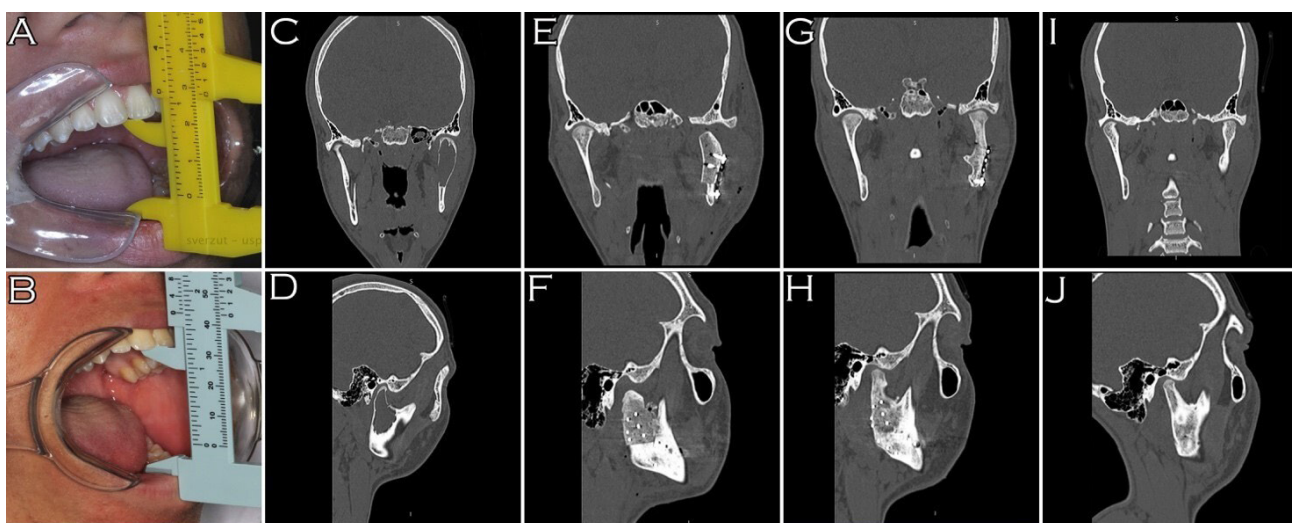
A, Preoperative restricted mouth opening (28 mm); B, Restoration of maximum mouth-opening amplitude on the 2-year follow-up (44 mm); C-D, Preoperative CT image showing the hypodense lesion in left mandibular condyle, circumscribed by a paper-like cortical bone and discrete facial asymmetry, coronal and sagittal sections, respectively; E-F, Immediate postoperative CT image showing the position of the bone graft, coronal and sagittal sections, respectively; G-H, 1-year postoperative CT image, showing the remarkable bone graft remodeling and integration to the native bone, coronal and sagittal sections, respectively; I-J, 2-year postoperative CT image, showing additional improvement in the bone graft remodeling resulting in a condyle-like shape, coronal and sagittal sections, respectively.
